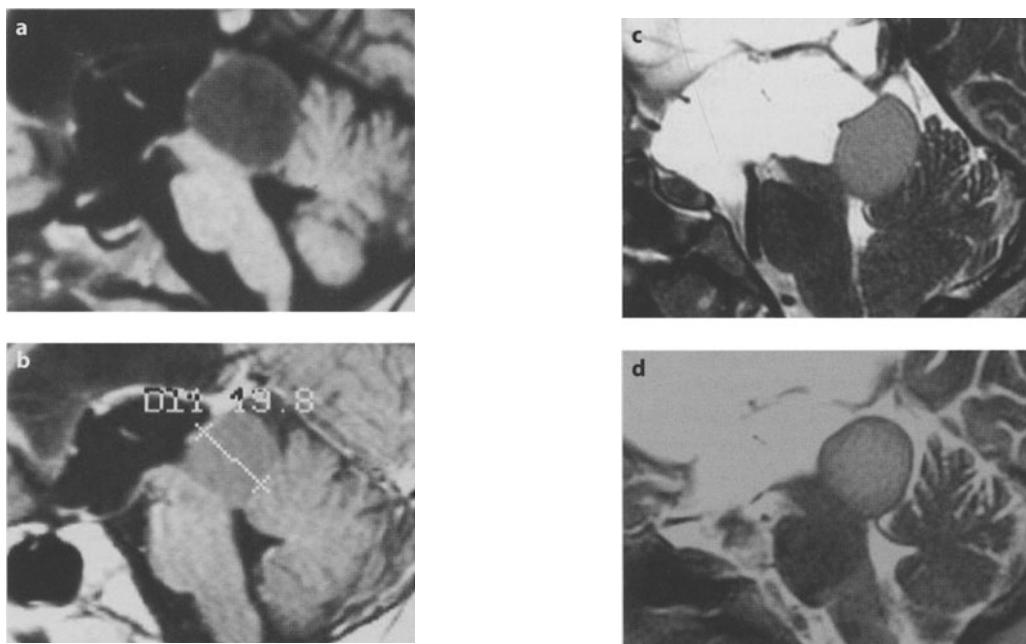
a One-year old baby girl presenting with obstructive triventricular hydrocephalus due to a large tumor of the tectal plate. Ventriculoperitoneal shunt was implanted and the parents refused surgery on the tumor. b Six years later, follow-up MRI showed shunt malfunction with mild increase of the ventricular system and no increase of the tectal mass. The patient was asymptomatic and the parents refused shunt revision. Note the deformation of the third ventricular floor, which bulges downward into the interpeduncular cistern. c Four years after b, follow-up MRI shows increased dilatation and deformation of the third ventricle, with severe flattening of the midbrain, erosion of the posterior clinoid processes, and the floor of the third ventricle bulging into the prepontine cistern. d Three months following endoscopic third ventriculostomy and shunt removal. The midbrain has a more normal shape and the floor of the third ventricle is in the normal position with a flow void artifact
